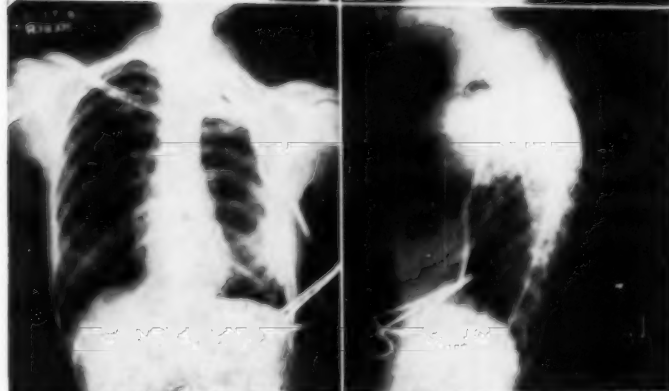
Case 1: Tuberculous empyema, left. Roentgenogram prior to treatment with tryptar. Figure 2—Case 1: Tuberculous empyema, left. Roentgenogram following second instillation tryptar. Intercostal tube in place.
